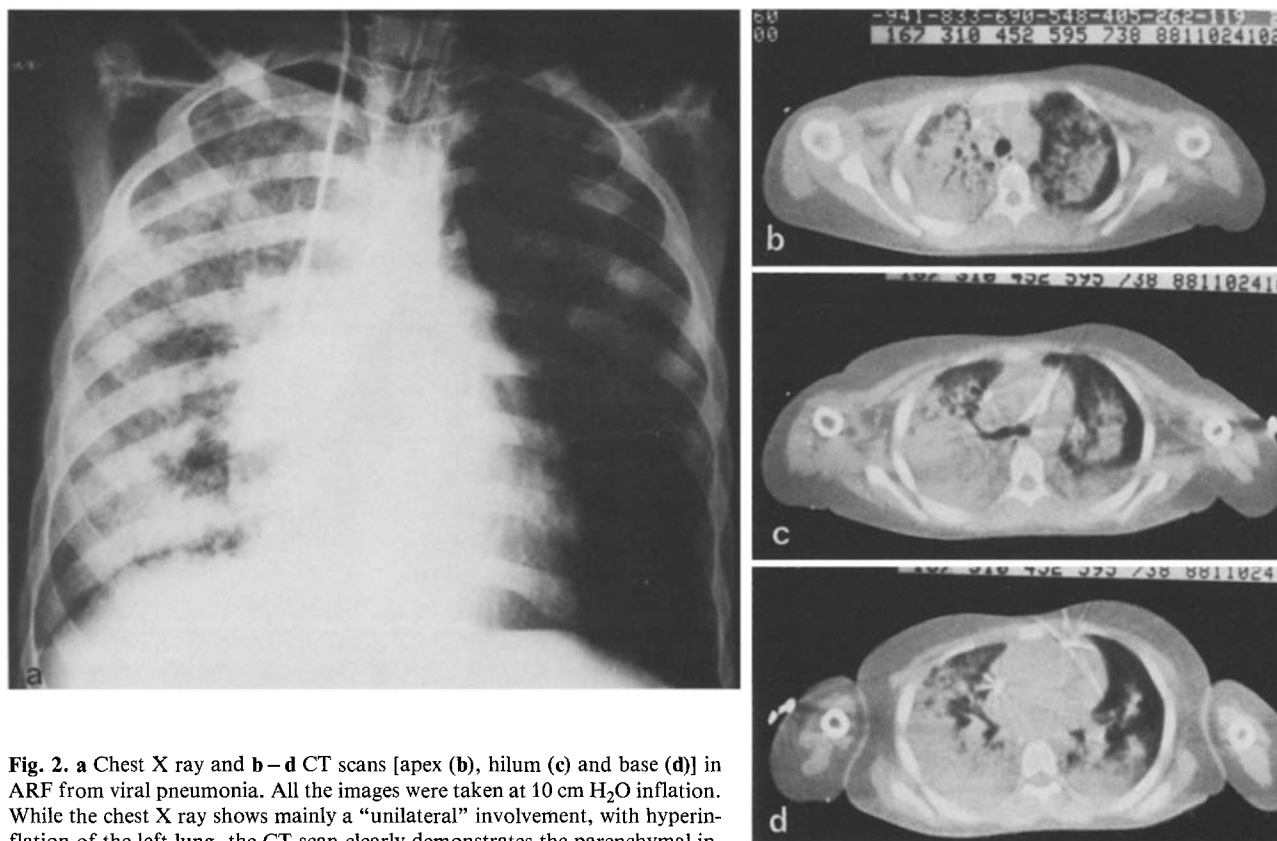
a Chest X ray and b–d CT scans [apex (b), hilum (c) and base (d)] in ARF from viral pneumonia. All the images were taken at 10 cm H₂O inflation. While the chest X ray shows mainly a “unilateral” involvement, with hyperinflation of the left lung, the CT scan clearly demonstrates the parenchymal involvement of the left lung
